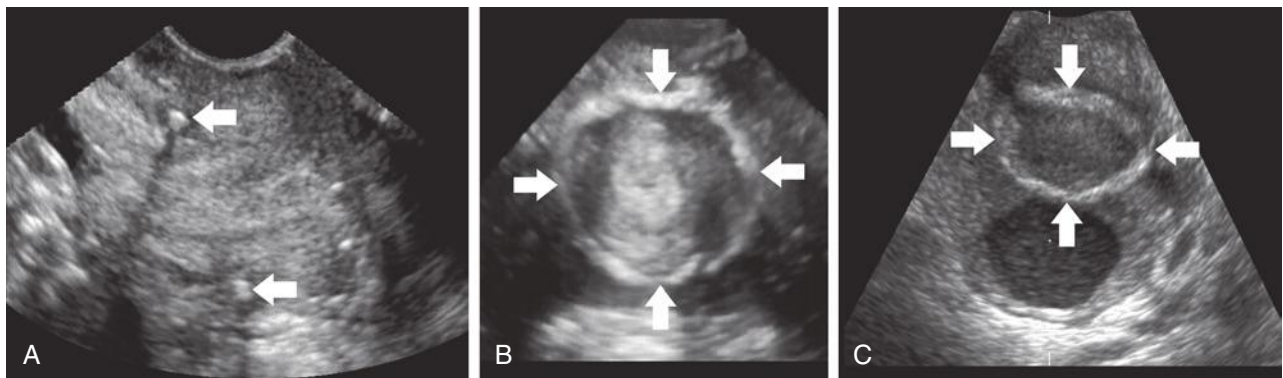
Transvaginal ultrasound images of the cervix with vaginal cerclage. A, Two-dimensional (2D) sagittal ultrasound image of the cervix. In this plane of section, the cerclage suture appears as two bright echoes (arrows) within the anterior and posterior cervical stroma, surrounding the endocervical canal. B, Three-dimensional (3D) ultrasound-derived image in the axial plane. In this view of the cervix, the vaginal cerclage suture is depicted in its entirety (arrows). C, 3D ultrasound-derived image in the axial plane. In this case, the vaginal cerclage suture (arrows) is well visualized and noted to have pulled through, located within the anterior lip of the cervix, anterior to the dilated endocervical canal.
